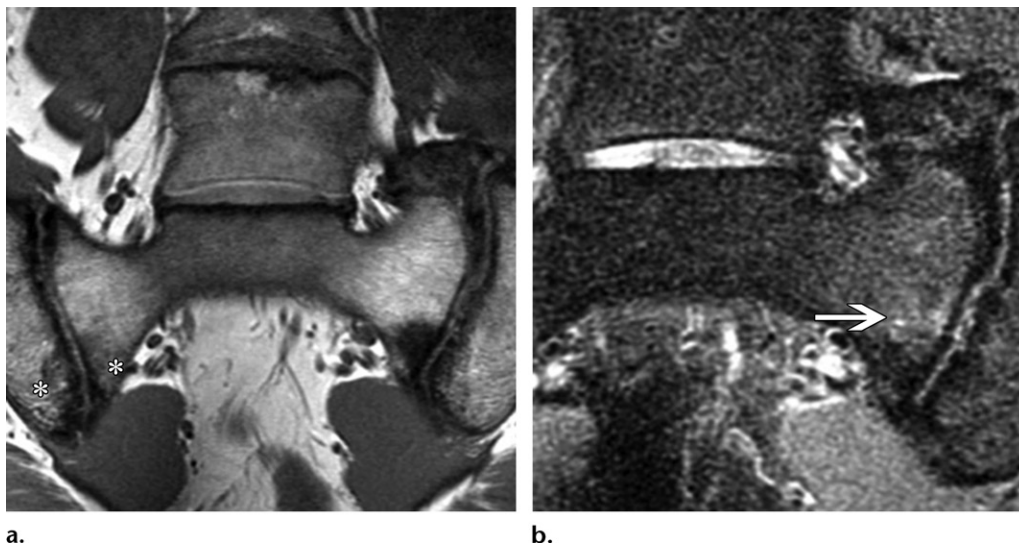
Acute inflammation in a 54-year-old woman with chronic sacroiliitis. Coronal T1-weighted (a) and STIR (b) MR images through the sacroiliac joints show irregularity along the articular margins (* on a) with subchondral sclerosis and edema (arrow on b), findings consistent with acute on chronic inflammation.
